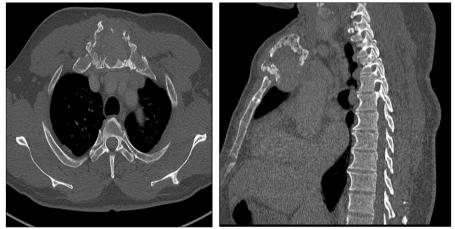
Thoraco-abdominopelvic computed tomography (bone window): Aggressive osteolysis of the sternal manubrium
